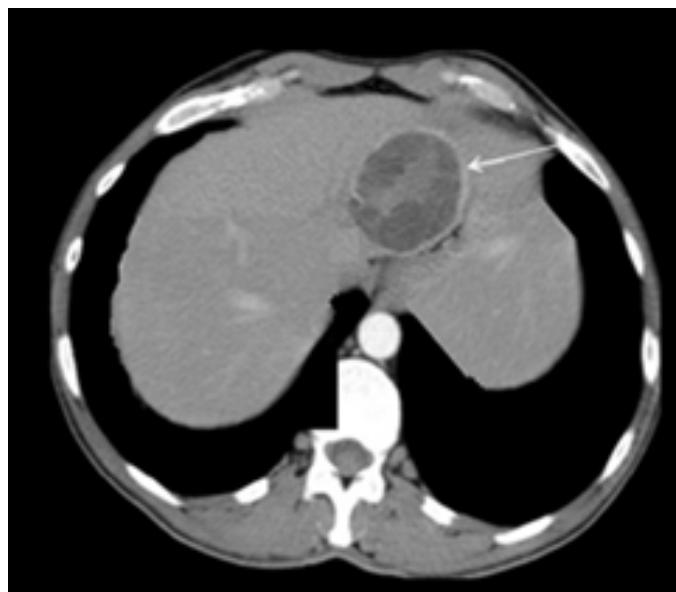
CT image shows a large hydatid cyst in the liver of a 53-year-old female
